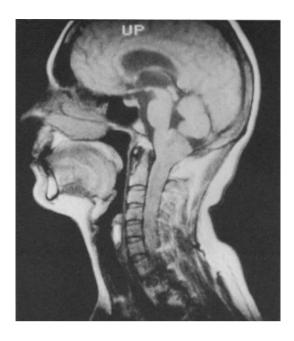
MRI of a 45-year-old patient with an ependymoma growing out of the brain stem and extending into the upper cervical spinal canal
